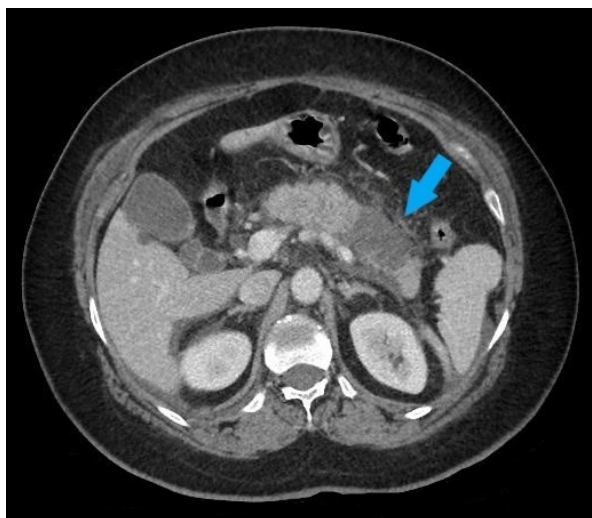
In the axial CT section, a hypodense area compatible with necrosis is observed in the body and tail of the pancreas (blue arrow).
